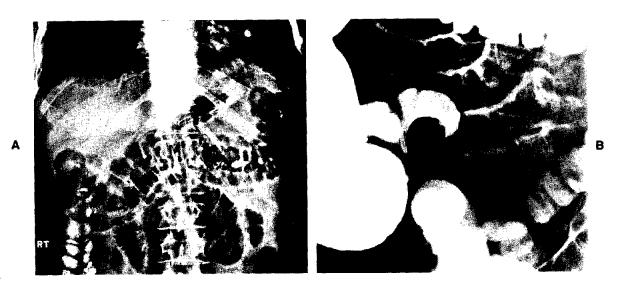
Radiographic features of patients with small bowel obstruction. A, Plain abdominal x-ray film showing small bowel dilatation. The patient had progressive, nonresolving obstruction caused by a single adhesive band; after laparoscopic division, the patient remains asymptomatic 4 years later. B, Hypaque enema demonstrates bowel obstruction 5 cm proximal to the ileocecal valve with multiple dilated bowel loops proximally. Multiple adhesions and a thick band with an internal hernia caused the obstruction. The patient was treated with laparoscopy only and remains asymptomatic 3 years later.
